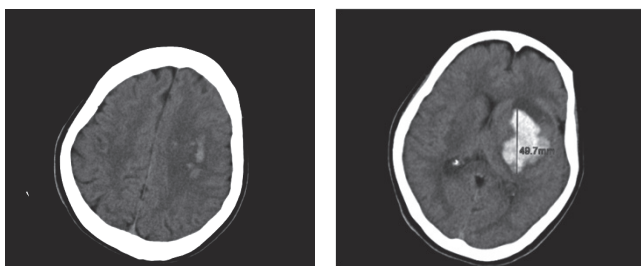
Initial computed tomography
